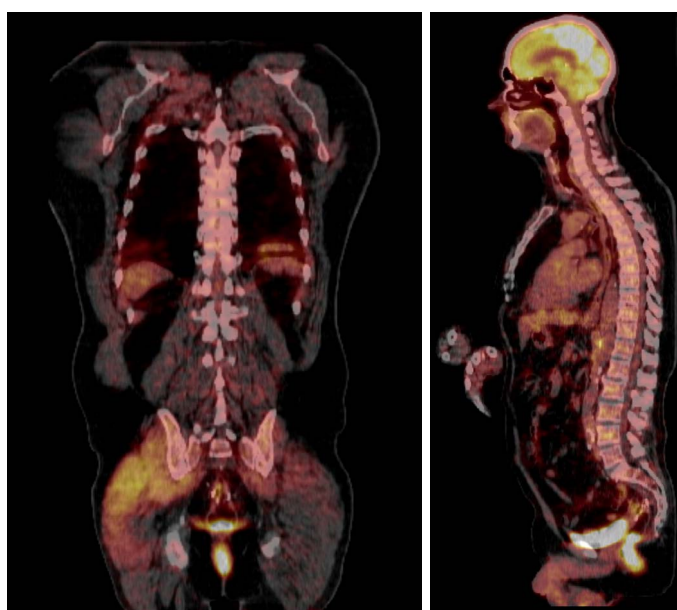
PET Scan (coronal and sagittal) showing no obvious signs of distant metastasis, but with an indeterminate AP window lymph node with abnormal FDG activity identified, and mild hypermetabolic activity in the left adrenal gland likely to be adenomatous change.
